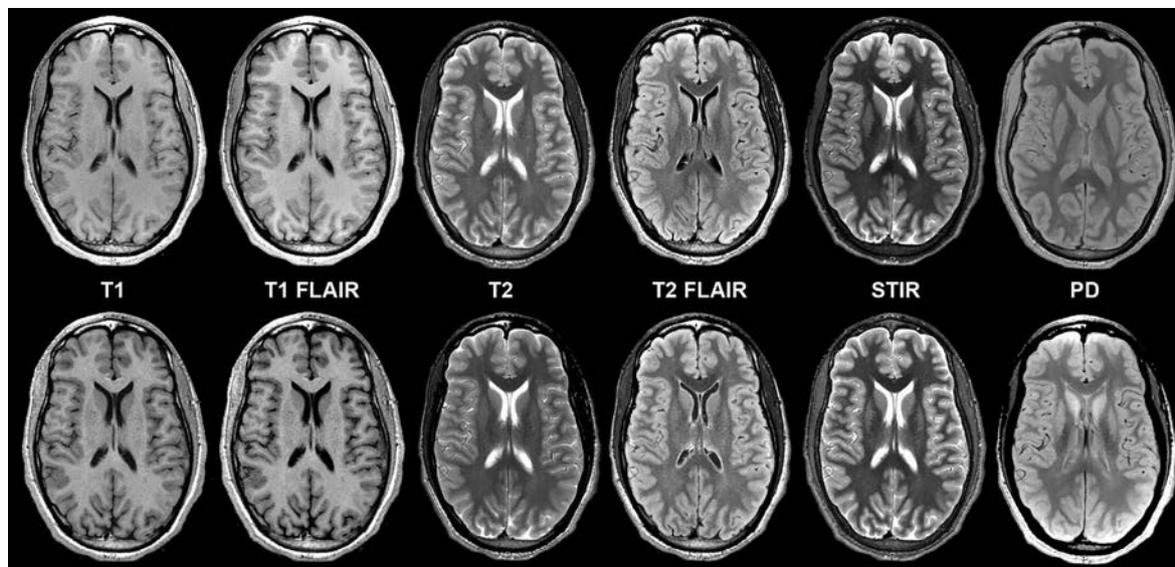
Axial synthetic and conventional 3T MR imaging of a normal brain. Conventional (*upper row*) and synthetic (*lower row*) image sets exhibit similar legibility and quality. Slight differences in contrast levels are apparent, which do not adversely impact the diagnostic utility of images, particularly between T1 FLAIR and T2 FLAIR views.
